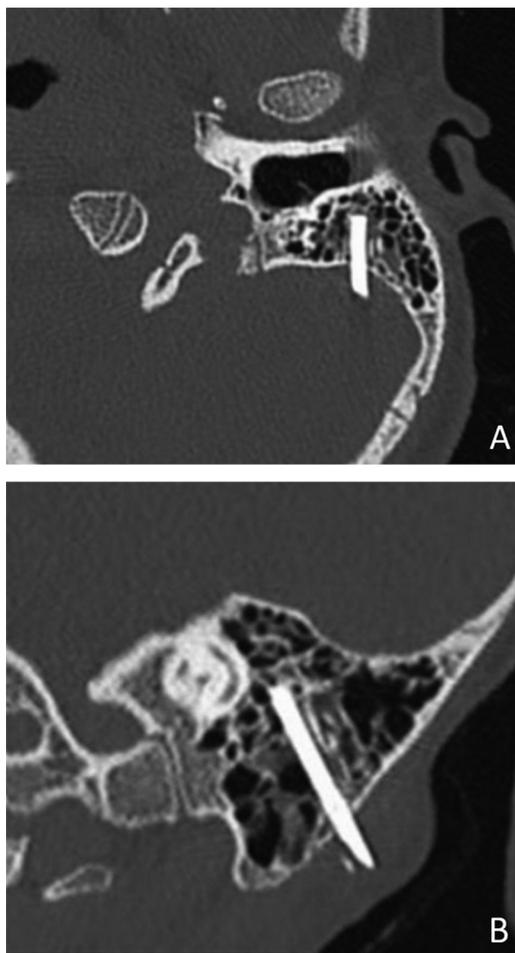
CT scan, axial (A) and coronal (B) sections, bone window setting. Transmastoid foreign body and suspected lesion of the left sigmoid sinus.
